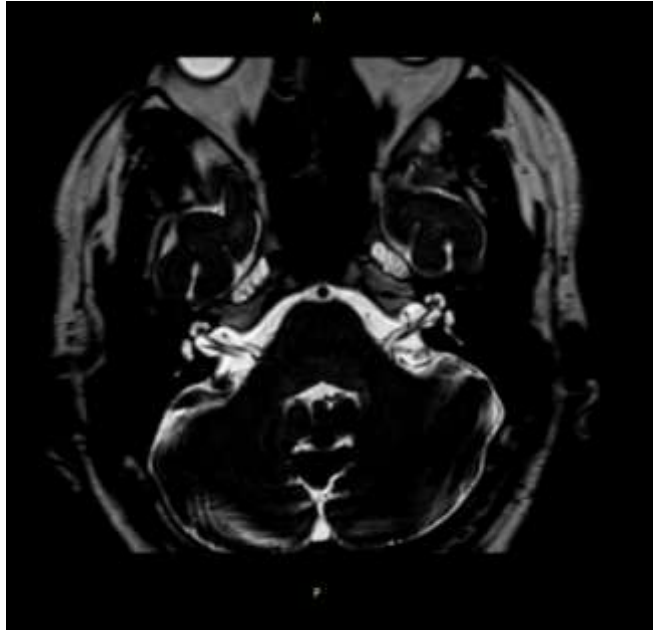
Axial MRI brain-IAC T2W-3D-DRIVE image for patient number 7 shows patulous IAC.
